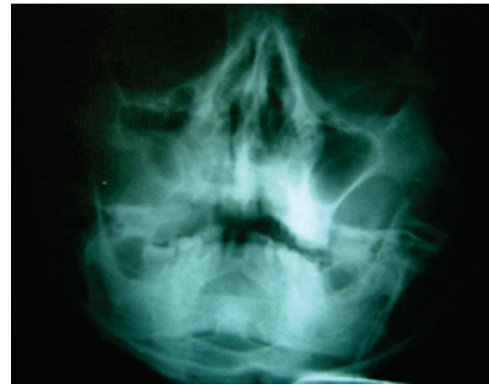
Radiograph (PNS) of sequestrum (right maxilla)
